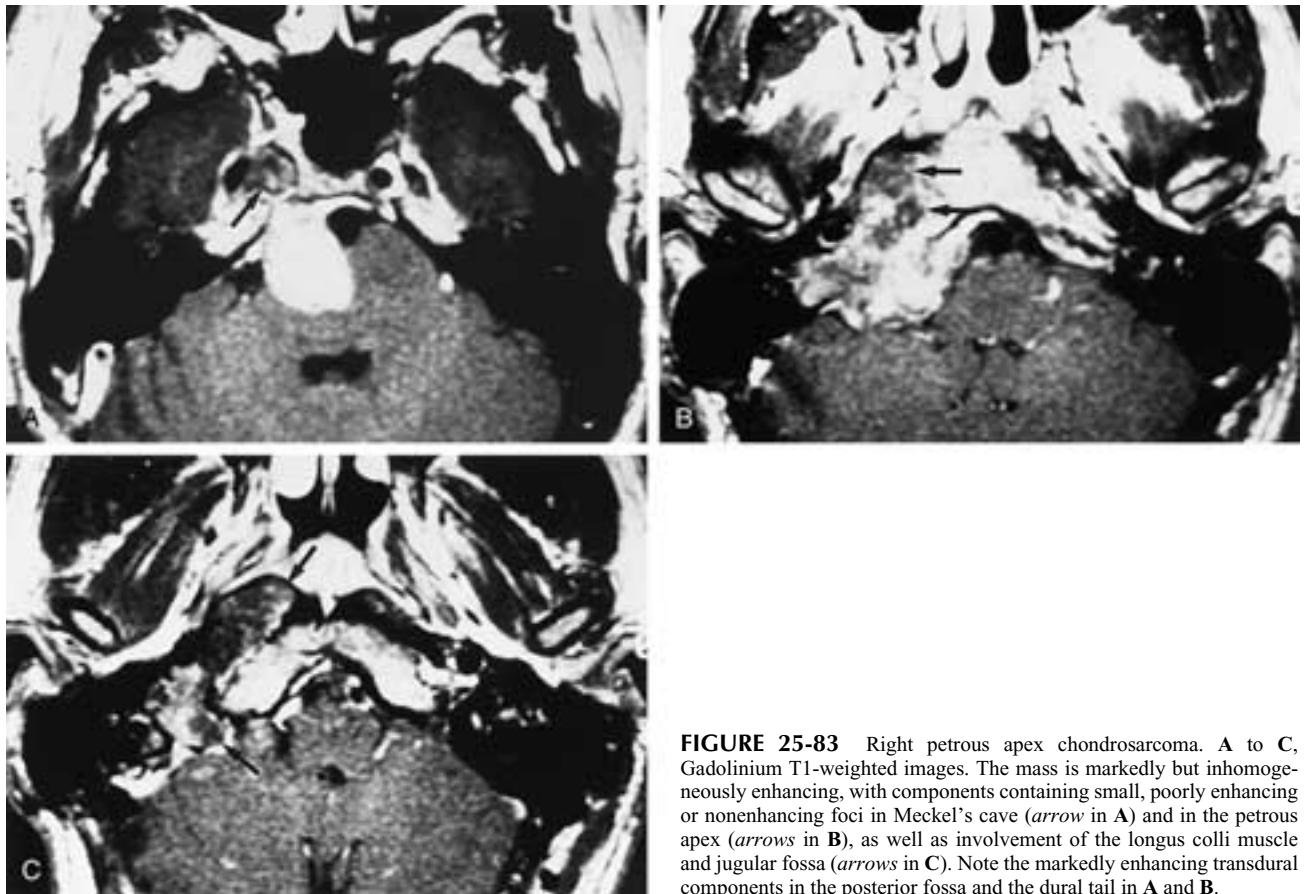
Right petrous apex chondrosarcoma. A to C, Gadolinium T1-weighted images. The mass is markedly but inhomogeneously enhancing, with components containing small, poorly enhancing or nonenhancing foci in Meckel's cave (*arrow* in A) and in the petrous apex (*arrows* in B), as well as involvement of the longus colli muscle and jugular fossa (*arrows* in C). Note the markedly enhancing transdural components in the posterior fossa and the dural tail in A and B.
